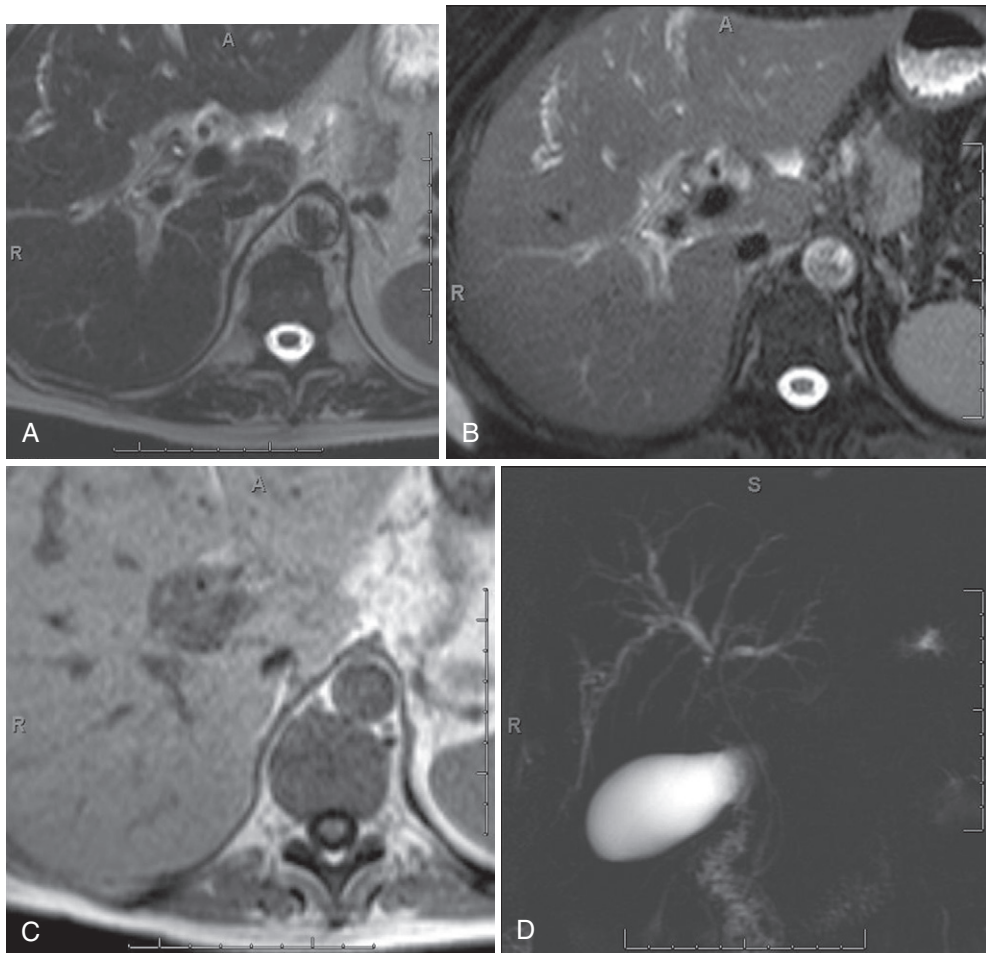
Cholangiocarcinoma with periductal-infiltrating growth pattern. T2-weighted (A), fat-suppressed T2-weighted (B), in-phase T1-weighted (C), coronal thick-slab MIP MRCP (D), and precontrast (E), early arterial phase (F), and delayed phase (G) fat-suppressed T1-weighted gradient recalled-echo images demonstrate gradually enhancing soft tissue about the extrahepatic bile duct causing intrahepatic biliary ductal dilatation in keeping with cholangiocarcinoma.
